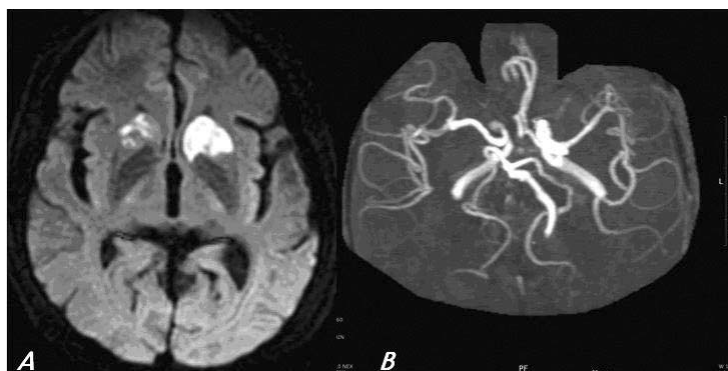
Follow-up MRI at the 7th admission day. (A) Diffusion weighted MRI still showed the bilateral caudate nuclei infarctions, predominantly on left. And newly developed putaminal infarction on left side. (B) Follow up MRA showed hypoplasia of the A1 segment of the right ACA.
